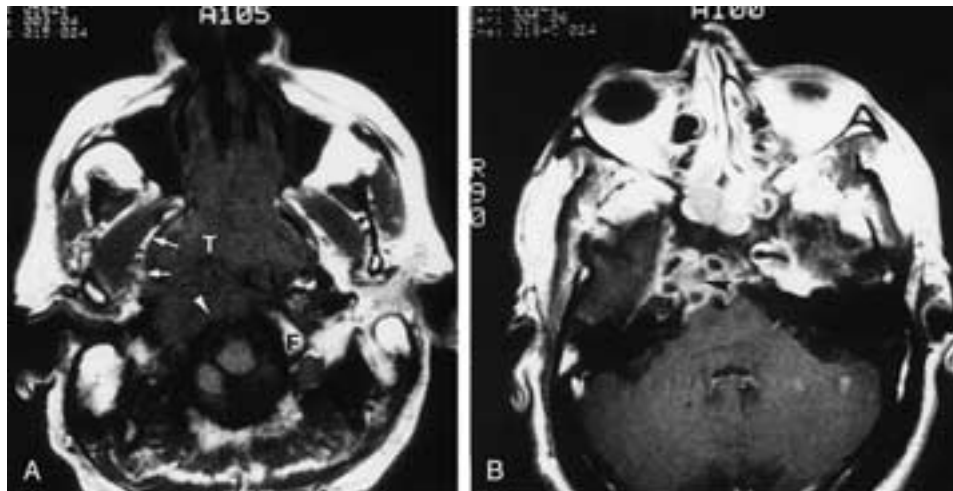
Nasopharyngeal carcinoma invading the basiocciput. A, The tumor (T) expands outward. There is a smooth expansion (*arrowheads*) of the wall of the nasopharynx without extension into the parapharyngeal fat. This demonstrates the strength of the fascial layers. Even though the tumor did not extend through the fascia, there is invasion of the bone (*arrowhead*), and there is obliteration of the fat within the medullary cavity and absence of the cortex. Compare this with the fat (F) in the occipital condyle on the normal side. MR imaging is very sensitive to tumor extension through the medullary fat. Small cortical erosions, however, can be missed. B, Postgadolinium image shows tumor extension (*arrowhead*) through the petrooccipital fissure at the lateral aspect of the sphenoid bone. Although enhancement can obscure the margins of the tumor below the skull base, it is helpful in demonstrating the tumor extent relative to the cavernous sinus and dural margin.
